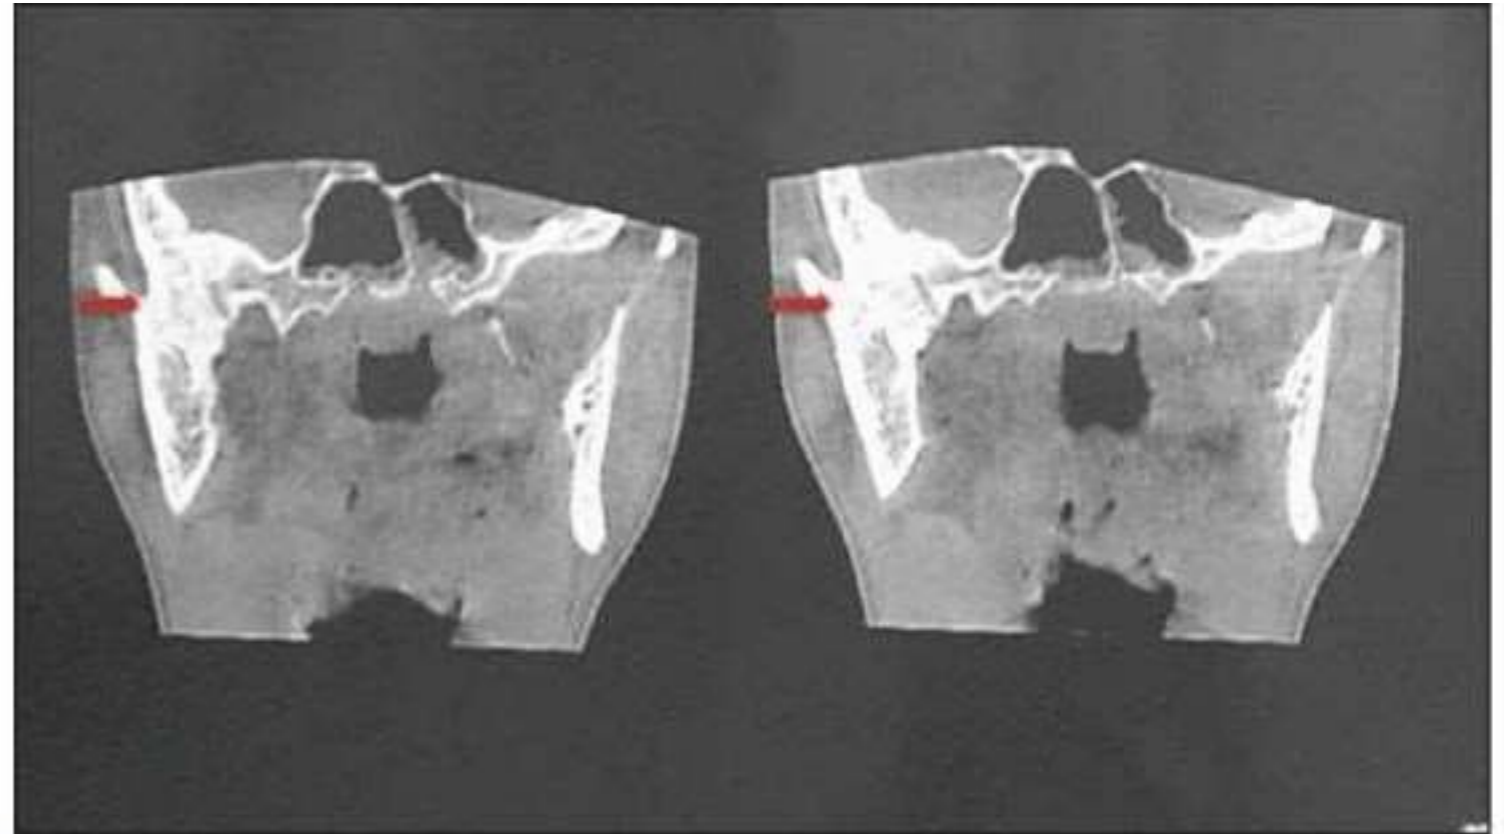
3D CT-scan showing TMJ ankylosis at the right side
